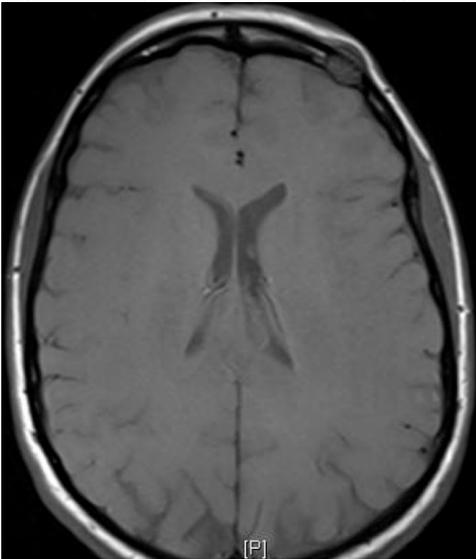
Axial magnetic resonance image showing intraosseous hemangioma.
